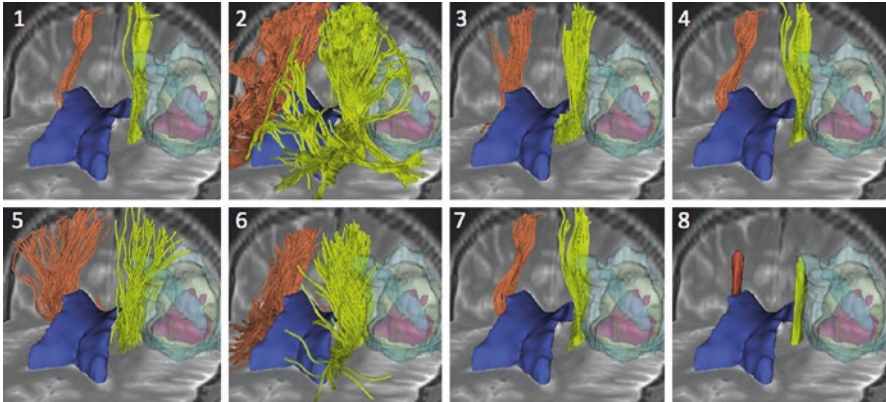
Variability of tractography results in the reconstruction of the pyramidal pathway. The mosaic image shows 3D anterior views of the pyramidal pathway reconstructed by eight tractography teams on a recurrent/residual anaplastic oligoastrocytoma WHO grade III. Each view presents the tracts (tumor side—*yellow*, contralateral side—*orange*) overlaid on an axial and a coronal T2-weighted image, along with 3D surface models of the tumor (*yellow*), necrosis (*pink*), edema (*light blue*) and lateral ventricles (*dark blue*). The teams are identified by a number, from 1 to 8, in the top left corner of each view. Source: DTI Challenge Project (<http://dti-challenge.org>)
